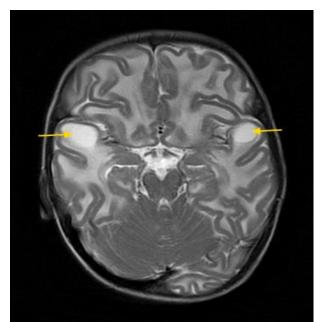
These cysts follow CSF signal in T2 MRI also ( arrows)
